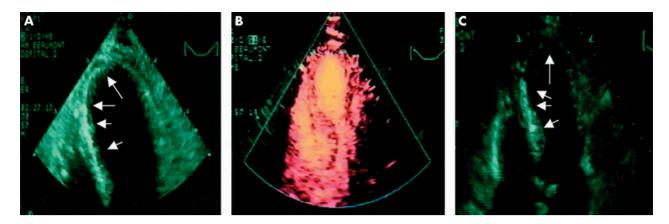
(A) Apical four chamber view in systole showing akinetic septum and apex (arrows) 12 hours after successful PTCA. (B) Homogeneous contrast opacification of the akinetic segments. (C) Follow up echocardiography at one month, showing recovery of function of these segments (arrows) with reduction of left ventricular end systolic value.
